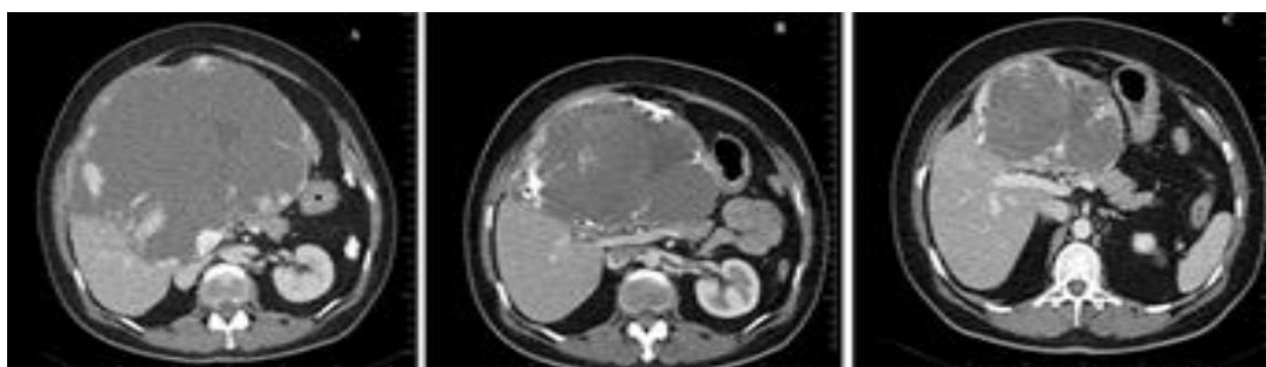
6 months patient follow-up of a large liver hemangioma; CT scan examination of the large liver hemangioma before embolization;(middle picture) CT scan follow-up 4 months after B/L embolization; then: CT scan 6 months after embolization (right one)
